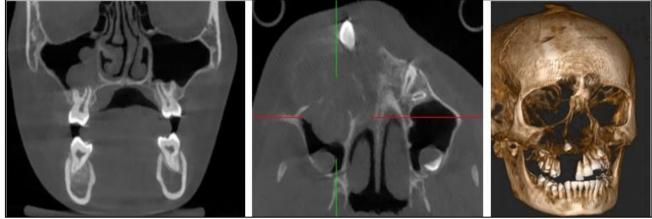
CBCT Imaging of the Maxillofacial Region.
